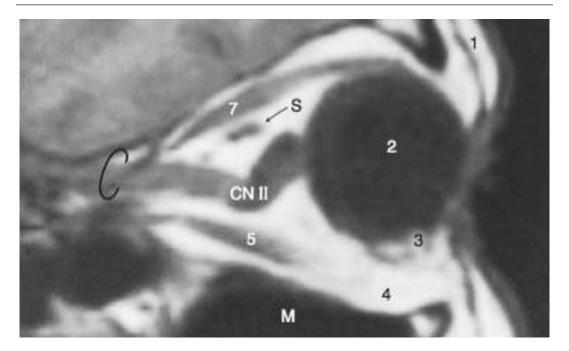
Mid-sagittal T1 MRI, lateral view of the orbit. Orbital contents: *I* orbicularis oculi muscle, *2* globe, *3* inferior oblique muscle, *4* retrobulbar (extraconal) fat, *5* inferior rectus muscle, *7* superior rectus muscle, *S* superior ophthalmic vein, *M* maxillary sinus, *CN II* optic nerve.
